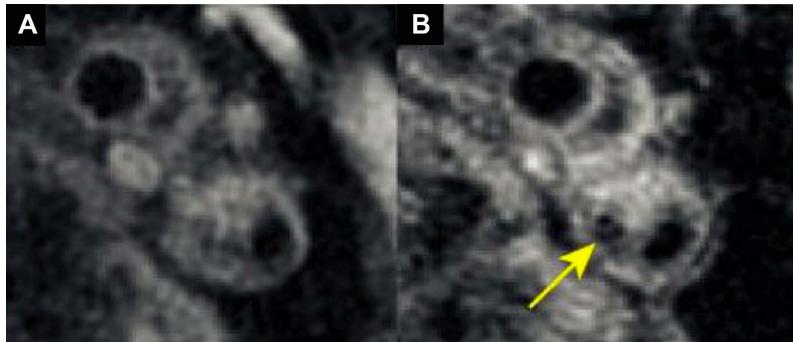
The T_2^* effect of USPIO as seen on QIR Spiral Acquisition. Pre (A) and post-USPIO (B) MR imaging of a symptomatic carotid plaque. Focal USPIO uptake is evident (yellow arrow head)
